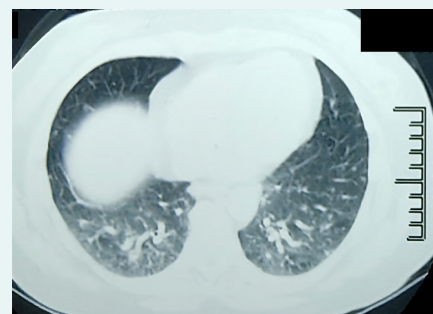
CT image of the lung window shows ground glass attenuation and multiple lung nodules in the lower lobes
